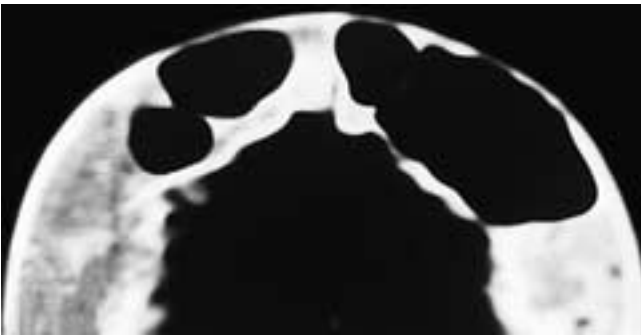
Axial CT scan shows large frontal sinuses in a patient with a dense cortical calvarium and hyperostosis interna. Despite the size of these sinuses, there was no deformity of the forehead or inner sinus table. This patient had hypersinuses.
